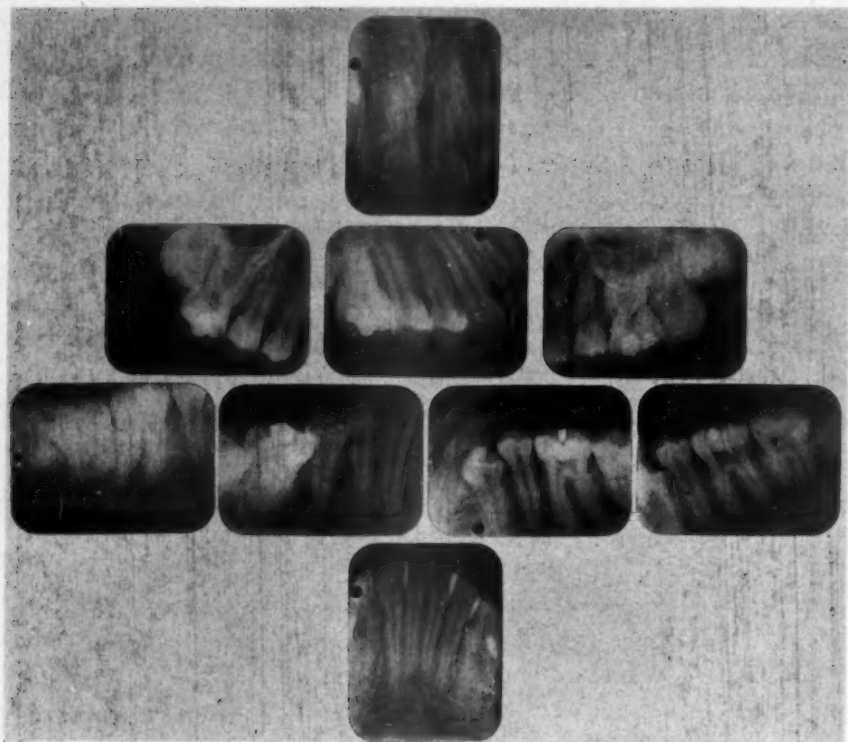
X-rays of teeth of H. G., taken Aug. 27, 1935, before treatment was started.
